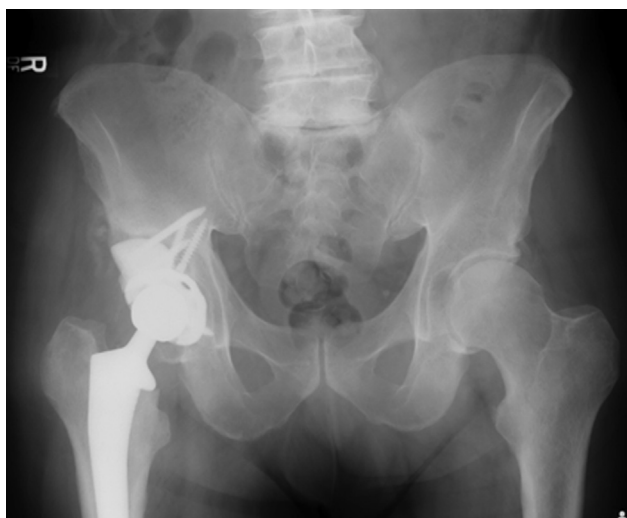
Immediate postoperative anteroposterior pelvis radiograph of case 1 with satisfactory position of component and restoration of leg lengths and hip center.
